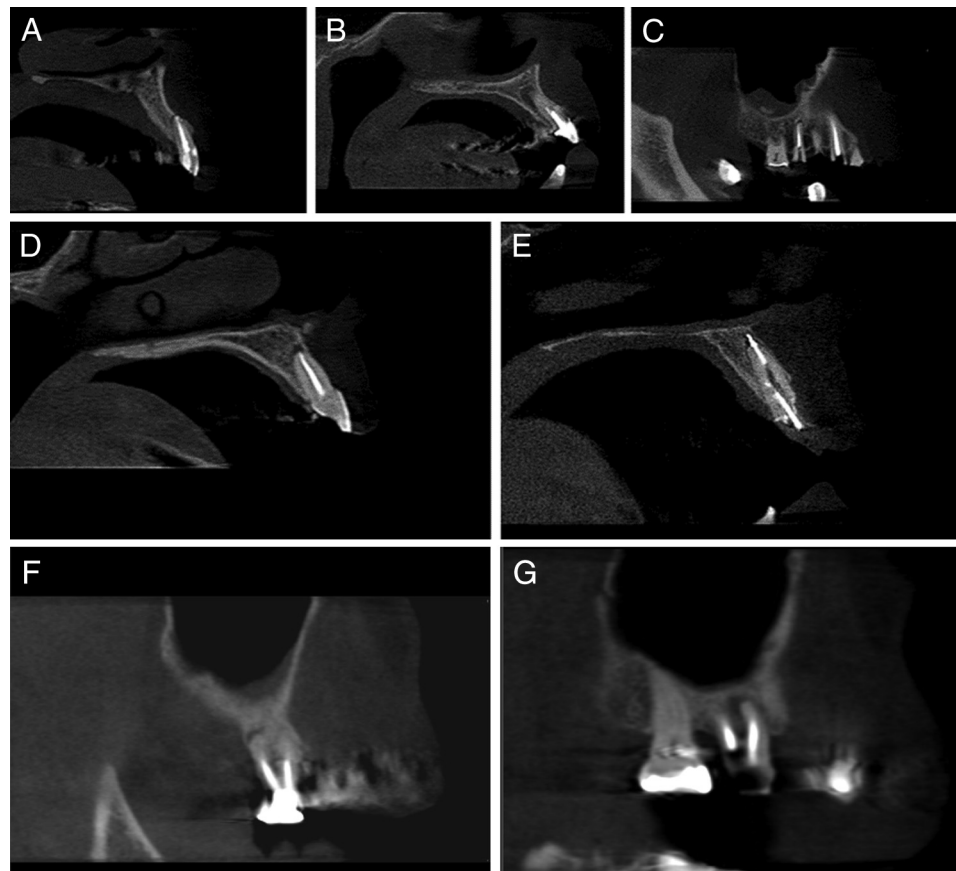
(A) Endodontic treatment appropriate, (B) endodontic treatment filling more than 2 mm short of the radiographic foramen, (C) absent coronal restoration, (D) apical radiolucency, (E) overfilling, and (F and G) multirrooted teeth ranked according to the root with the worst evaluation.
